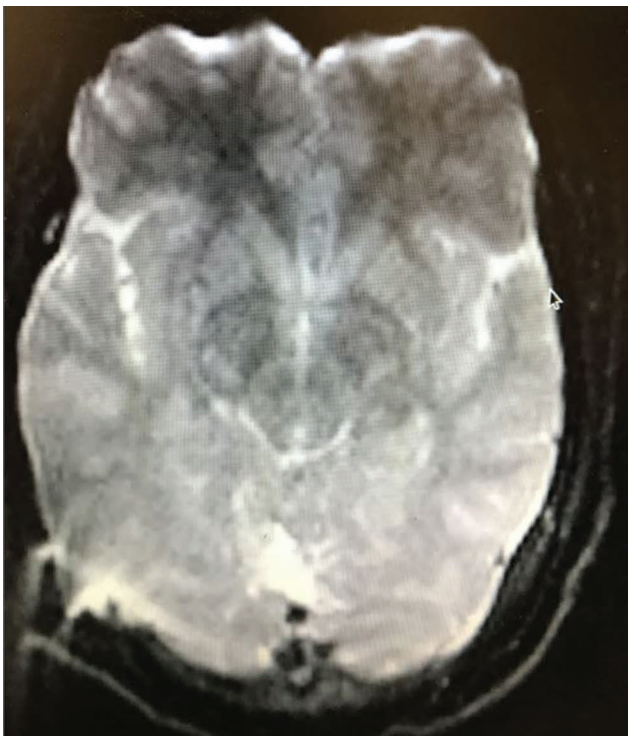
Postoperative MRI showing complete excision.
